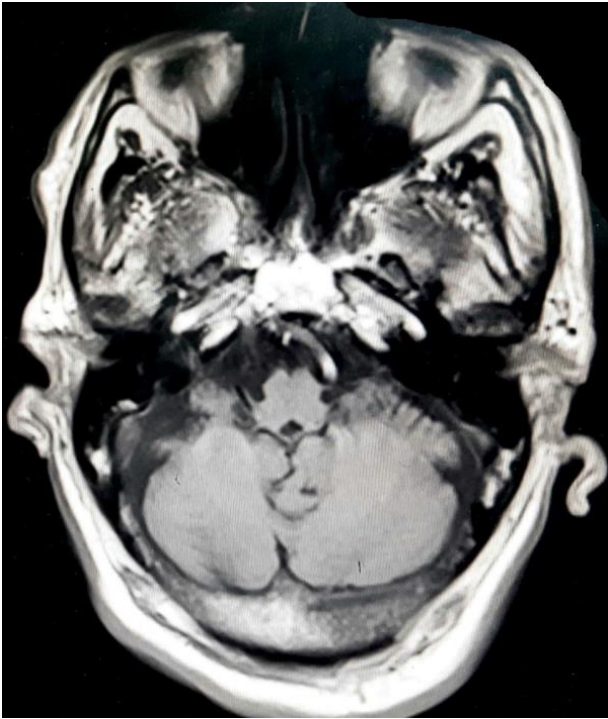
MRI T1 scan (in 2020) for the brain which shows the basilar artery out of the pre-pontine groove and crossing from the left side to the right side.
